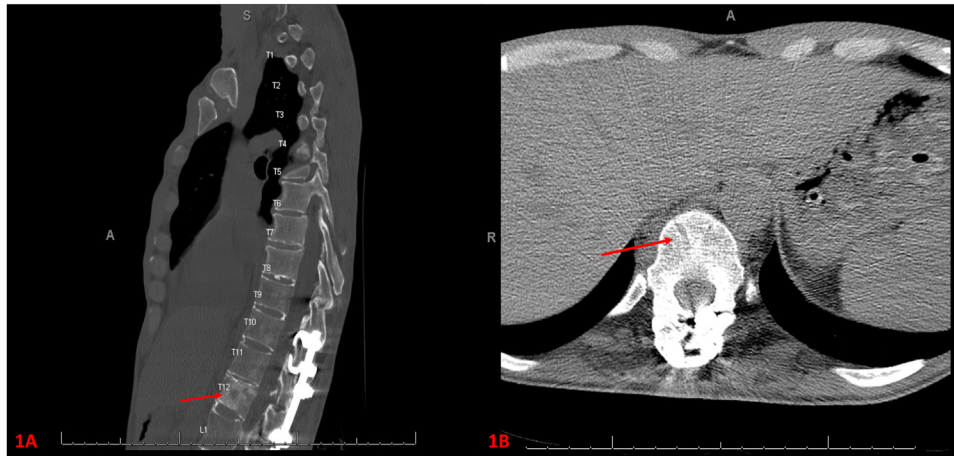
Imaging showed a patient with a history of recurrent lumbar infection status post washout. The patient was on dalbavancin and fluconazole for MRSA and *Candida* in cultures. Figure A/B: A CT scan without contrast shows the pedicles and body of the T12 vertebra exhibiting a heterogeneous, mixed lytic sclerotic appearance with mild anterior wedging.
